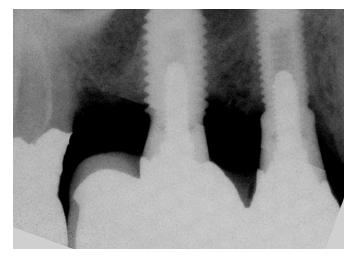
Periapical radiograph demonstrated metal-to-metal contact between the retainers of the FPD and the abutments.
